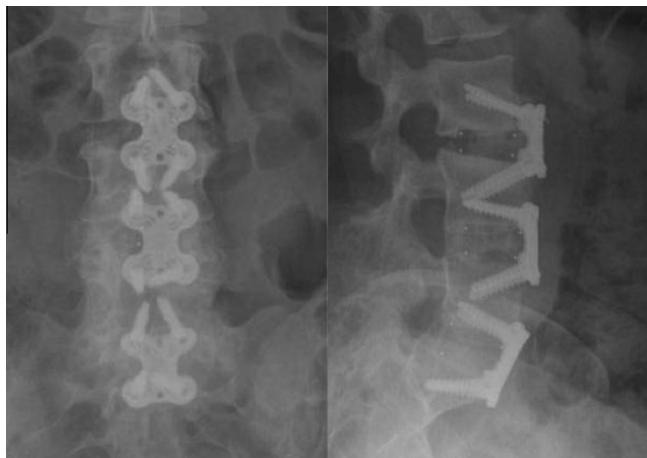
(Left) Anteroposterior and (right) lateral radiographs showing multilevel anterior lumbar interbody fusion.
